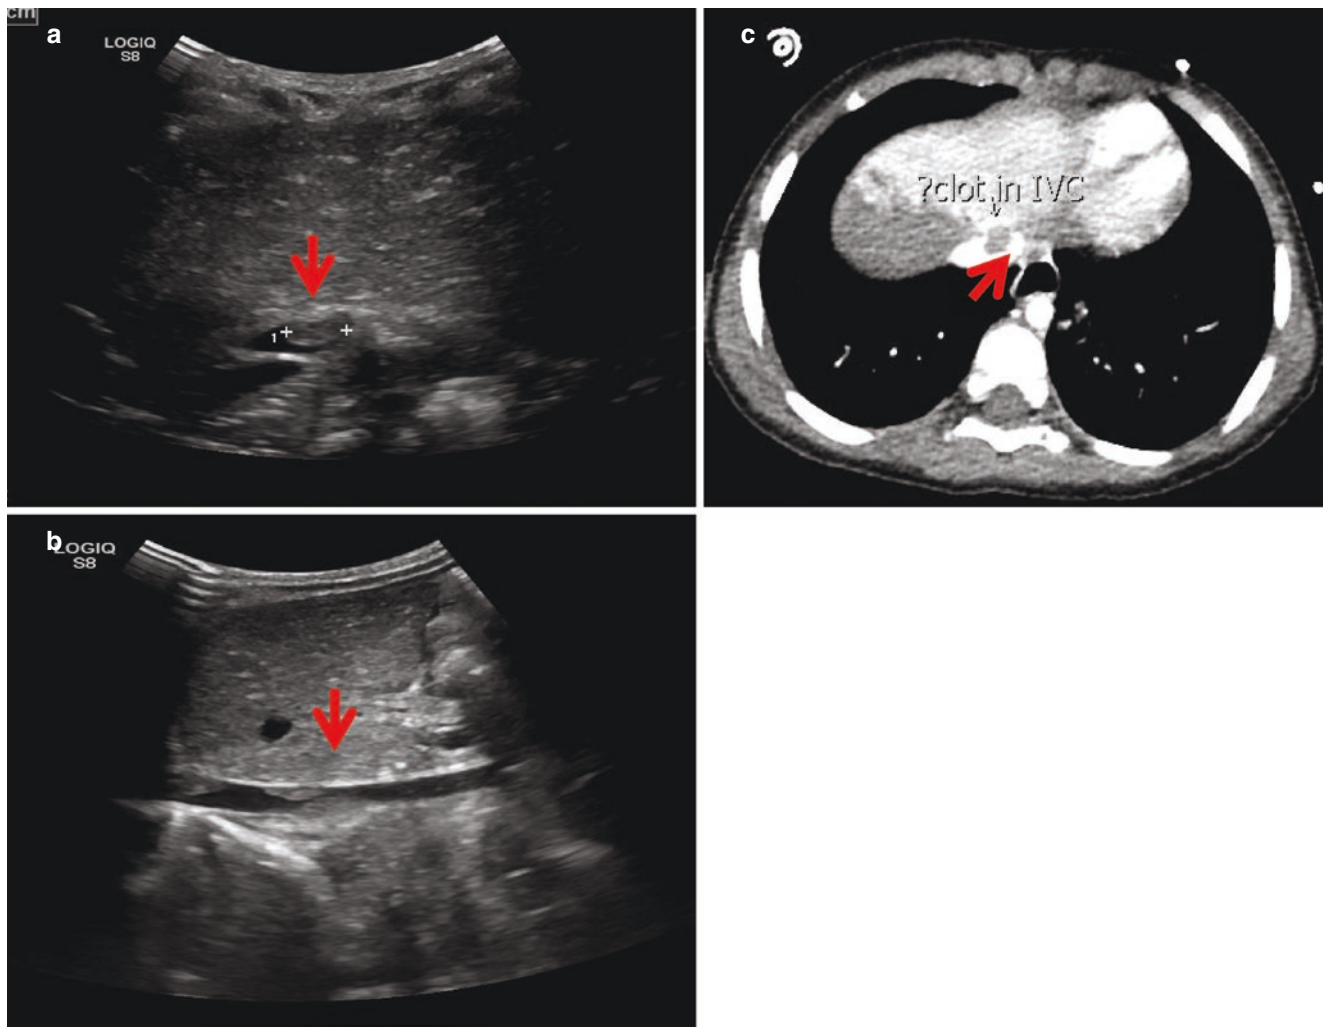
Axial Doppler Scan (US) of the liver (a and b) and Intravenous contrast enhanced axial scan of the liver with Camp bastion wheel protocol (c), reveals laceration of the liver with non-occlusive thrombus within the IVC
